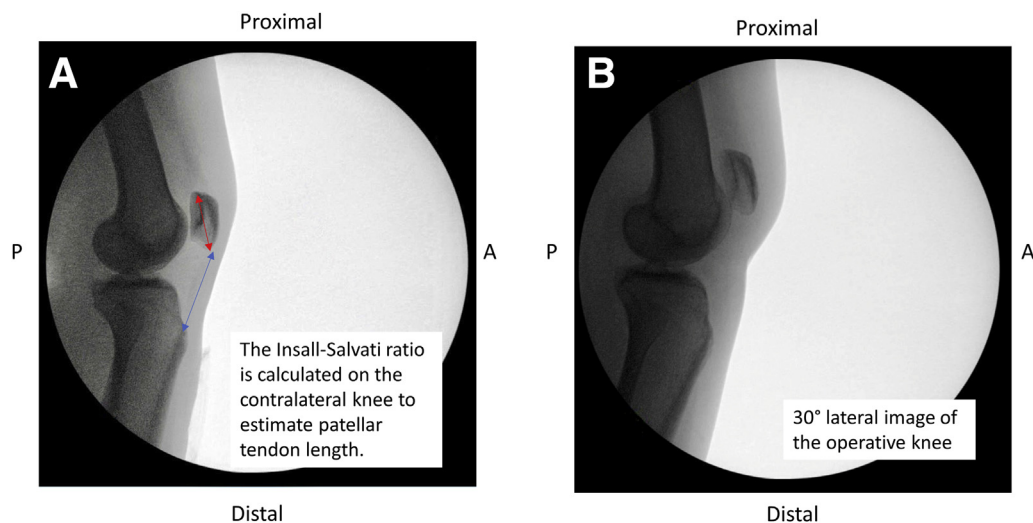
Intraoperative radiographic imaging. Before sterile draping, fluoroscopy is used to obtain true 30° lateral images of the operative and contralateral knees. To appropriately restore patellar height, the contralateral knee is used to calculate the baseline Insall-Salvati ratio and estimate the patellar tendon length. (A) A 30° lateral fluoroscopic image of the contralateral right knee. The red line represents the greatest pole-to-pole patellar length. The blue line represents the patellar tendon length. (B) A 30° lateral image of the operative left knee before restoration of patellar height, showing patella alta and deficiency of the patellar tendon. (A, anterior; P, posterior.)
